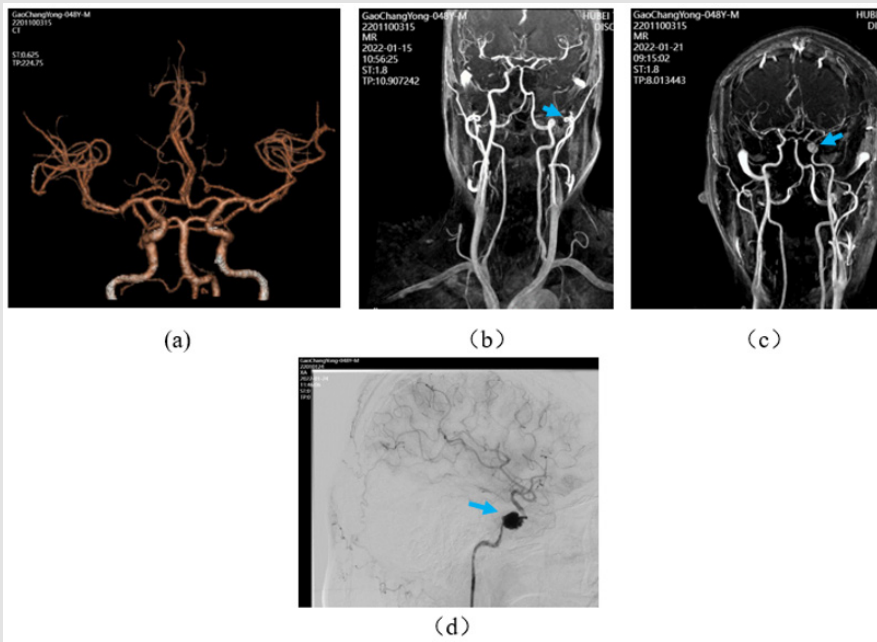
CTA, MRA and DSA of blood vessel of brain.
